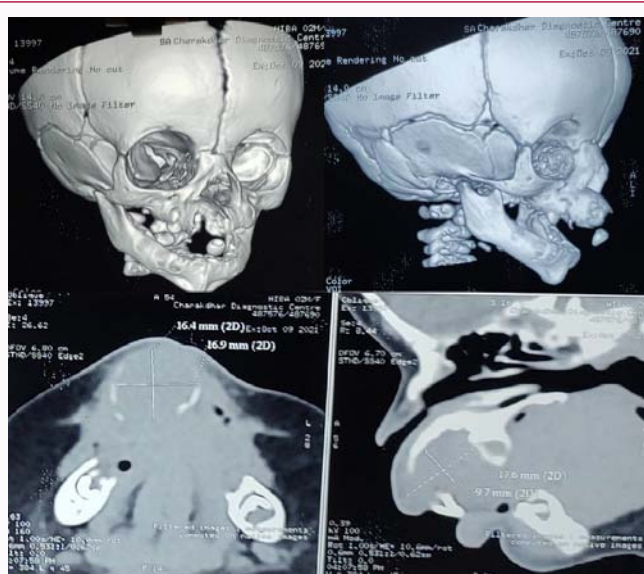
Computed tomographic scan of showing the extent of lesion.
